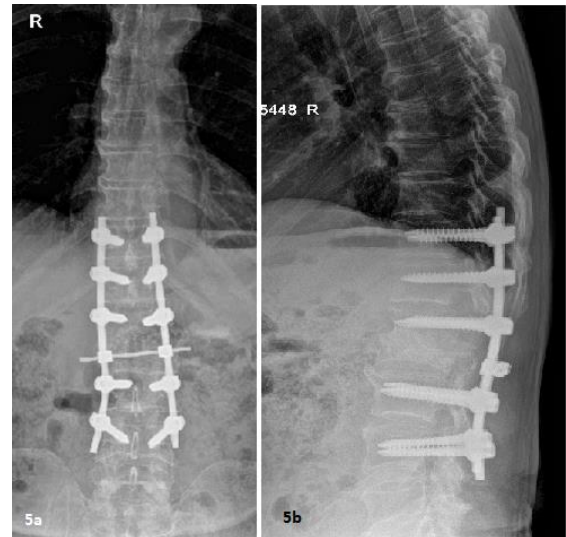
Post-op radiographs showing T11-L4 posterior instrumented fusion.
